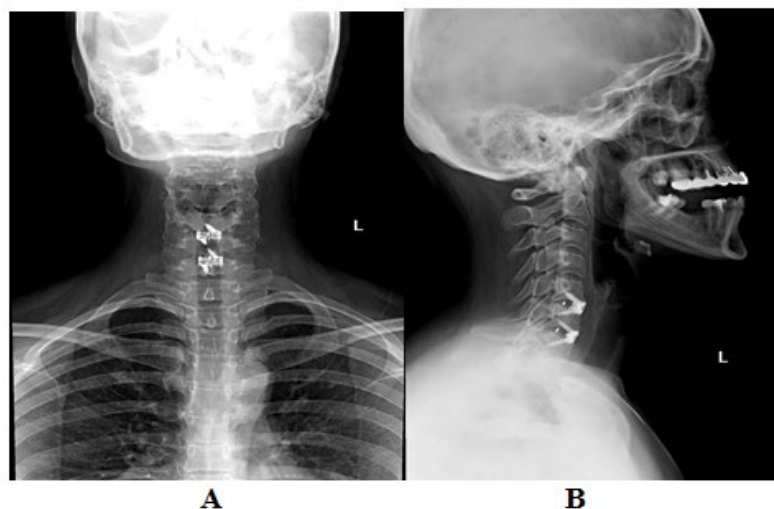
Radiographs taken at three months follow up in AP and Lateral view in figures A and B respectively
